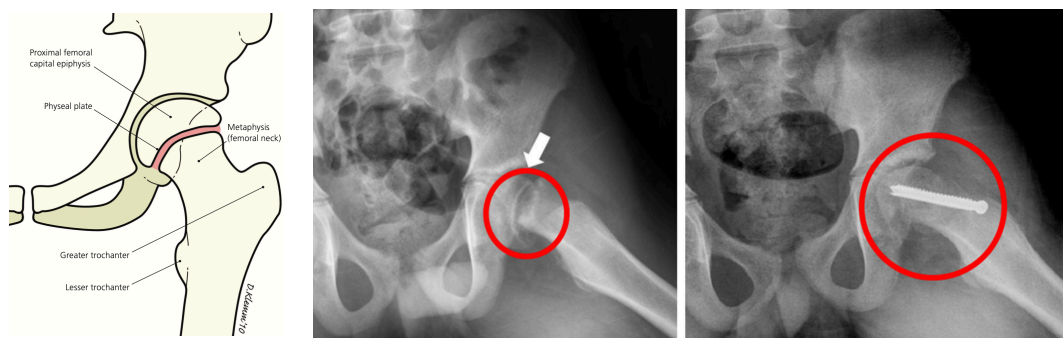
(Left) Anatomy of the hip [92], (Middle) Radiograph of a SCFE case (arrow), (Right) Fixation of the SCFE
